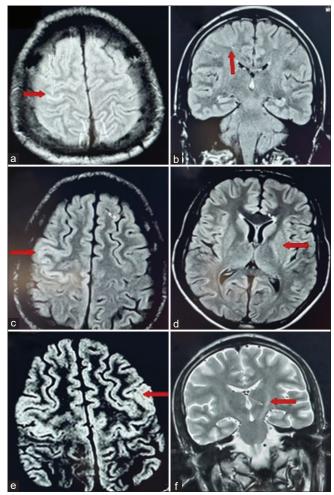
Magnetic resonance imaging brain: (a and b) Arrows highlight the hyperintensity and subtle dedifferentiation of the gray-white interface at the precentral gyrus in axial and coronal views, respectively. (c and d) Arrows point to hyperintensities in the entire right motor cortex and the left globus pallidus on axial sequences. (e) Arrow indicates the hyperintensity in the left motor cortex on an axial sequence. (f) Arrow emphasizes the hyperintense signal involving the left corticospinal tract on the coronal T2 sequence
